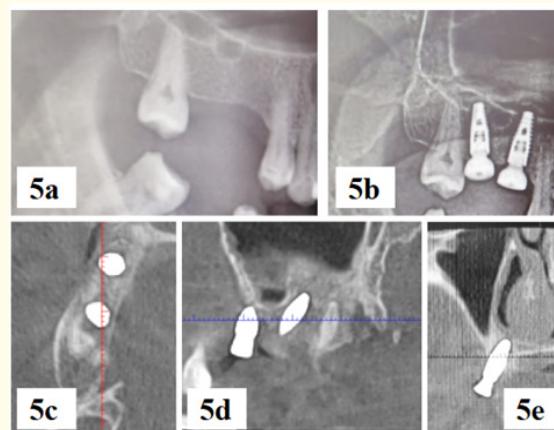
5a. Preoperative panoramic radiograph, showing the edentulous #15 and #16 regions with reduced bone height. 5b. Postoperative panoramic radiograph, confirming successful implant placement following internal sinus lifting. 5c. Postoperative CBCT axial view, demonstrating the positioning of both implants within the augmented bone structure. 5d. Postoperative CBCT sagittal section, showing successful sinus elevation and implant integration. 5e. Postoperative CBCT coronal section, confirming implant stability and maintaining sinus integrity.
